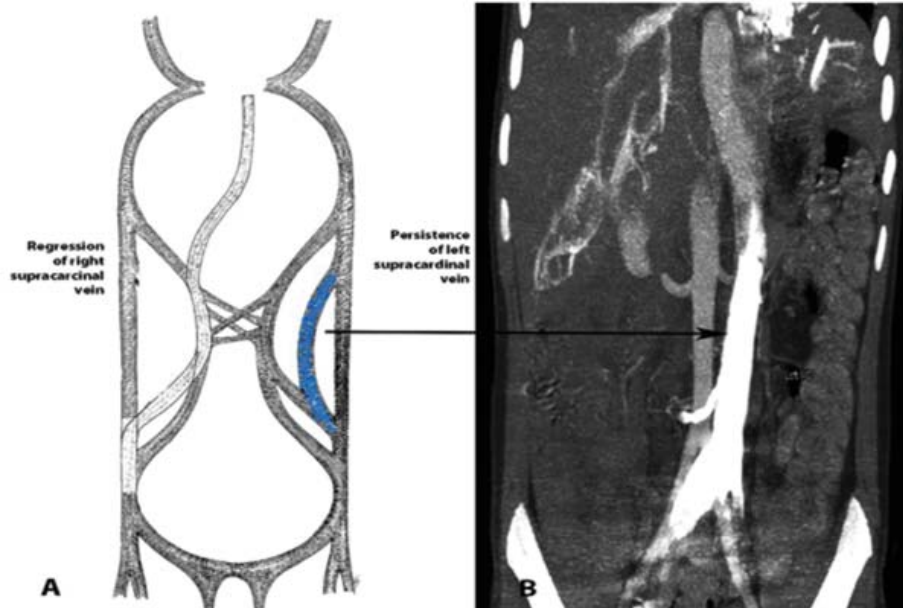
Left IVC. A – Embryonic etiology of the left IVC. B - abdominal CT in the coronal plane. The contrast-enhanced left vena cava is positioned on the left side
